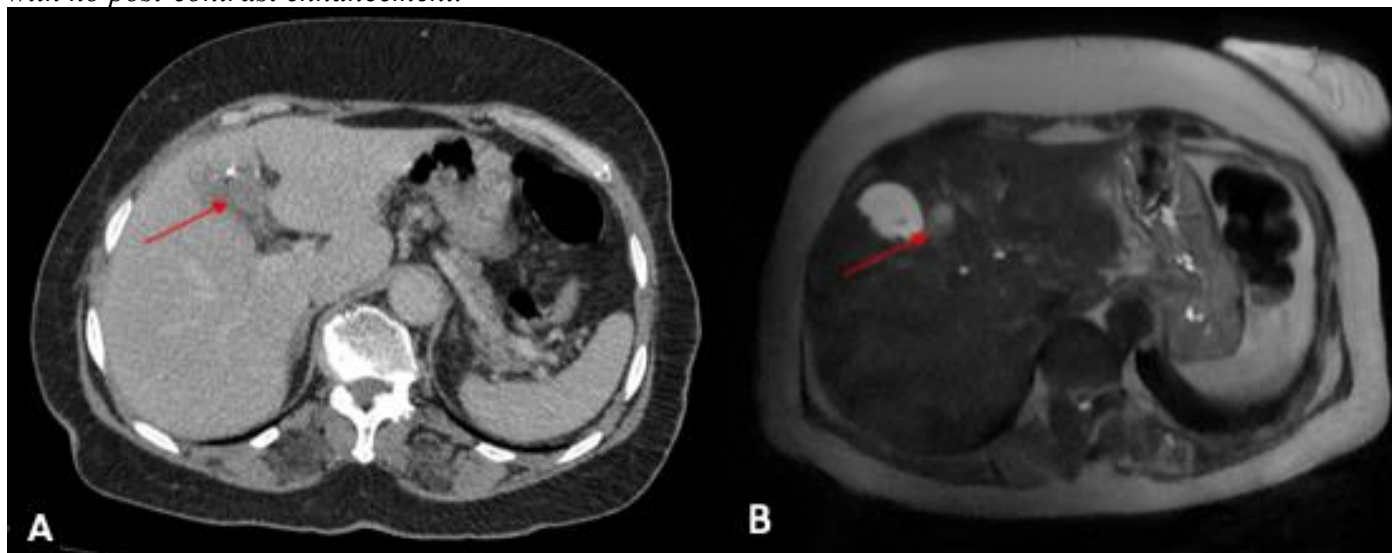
CT (A) and MRI (B) images demonstrating a hepatic lesion (red arrow) consistent with a hydatid liver cyst.
